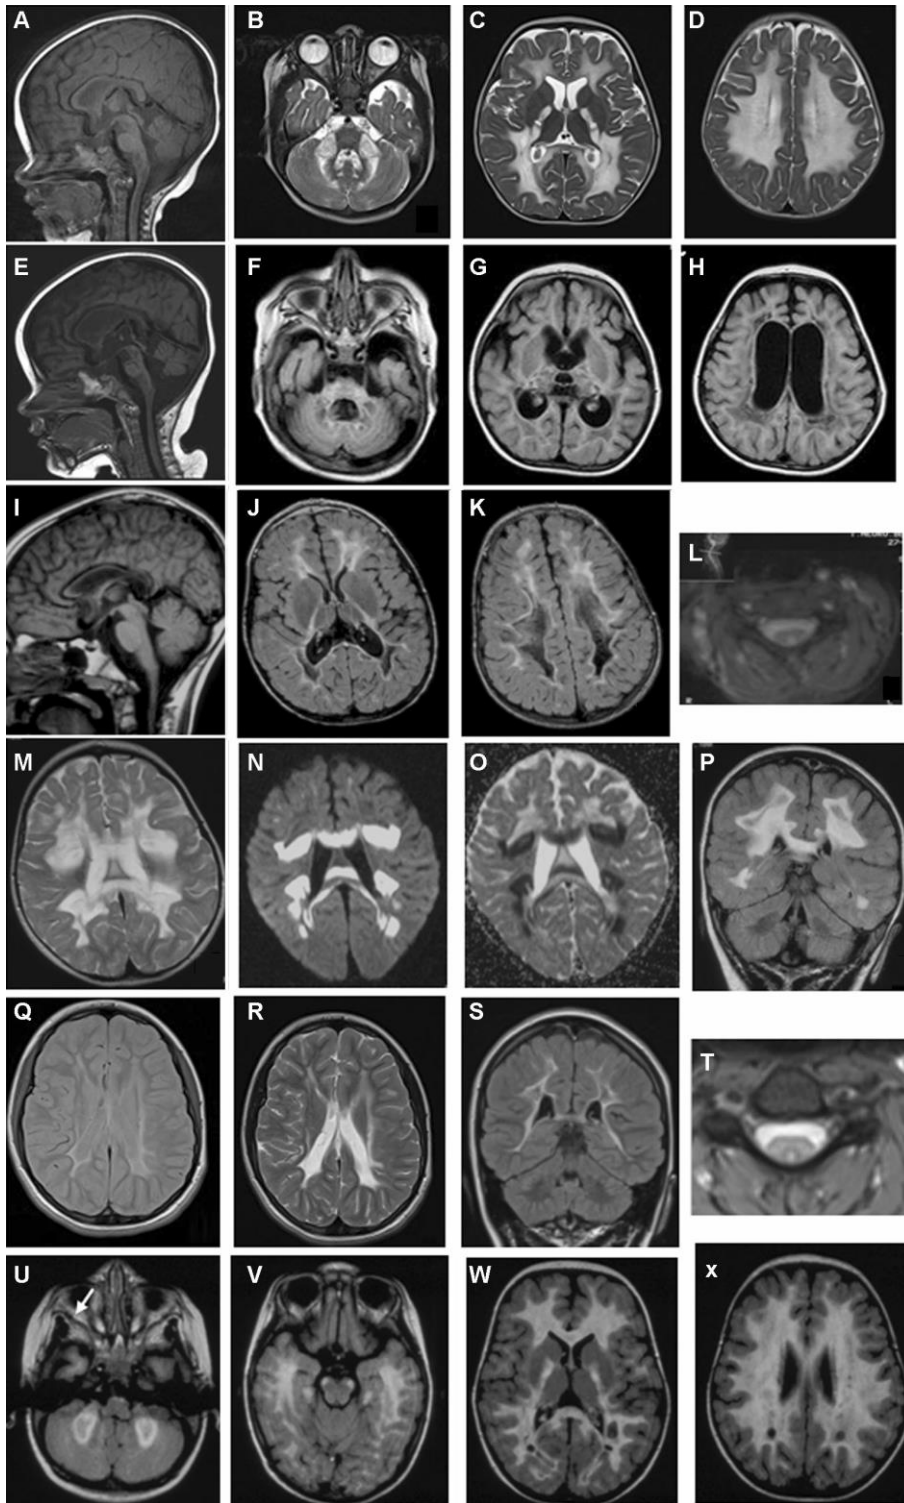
Pt.1: Sagittal T1-wi (a) and axial T2-wi (b–d) in the early stage; sagittal T1-wi (e) and axial FLAIR images (f–h) in the late stage. Hypointensities in the corpus callosum, brainstem and upper spinal cord (a). Signal abnormalities in the cerebral white matter also involved corpus callosum, posterior arm of the internal capsulae and middle cerebellar peduncles (b–d), cavitations in the internal capsulae (c). Marked white matter atrophy and cavitations with cystic degeneration (g, h). Additional lesions in brainstem (e), thalami (g) and corpus callosum and brainstem atrophy (e). Pt.2: Late MR, Sagittal T1-wi (i) Axial FLAIR images (j, k): diffuse leukoencephalopathy extended to the corpus callosum and posterior arm of the internal capsulae (i, j) cavitations marked posteriorly (j, k). Cervical MRI Axial T2-wi (l): signal abnormalities in the posterior column of the cervical spinal cord. Pt.3: Axial T2-wi (m–o), DWI (n), apparent diffusion coefficient (ADC) image, and coronal FLAIR image (p) in the acute phase; axial proton-density (q) and T2-wi (r), and coronal FLAIR image (s) in the late phase. Diffuse white matter signal abnormalities (m–o). Cavitations in the frontal (n) and parietal white matter (p); restricted diffusion in the non-cavitated white matter (n). White matter atrophy (q–s) U-fibers look spared (q). Additional hyperintensities in the cervical spinal cord (t). Pt.4: Late MR Axial FLAIR images (u–x) diffuse involvement of hemispheric white matter extended to corpus callosum and internal capsulae (u–x). Rarefaction of the deep white matter (u, v) and appearance of small cysts (w, x); symmetric
